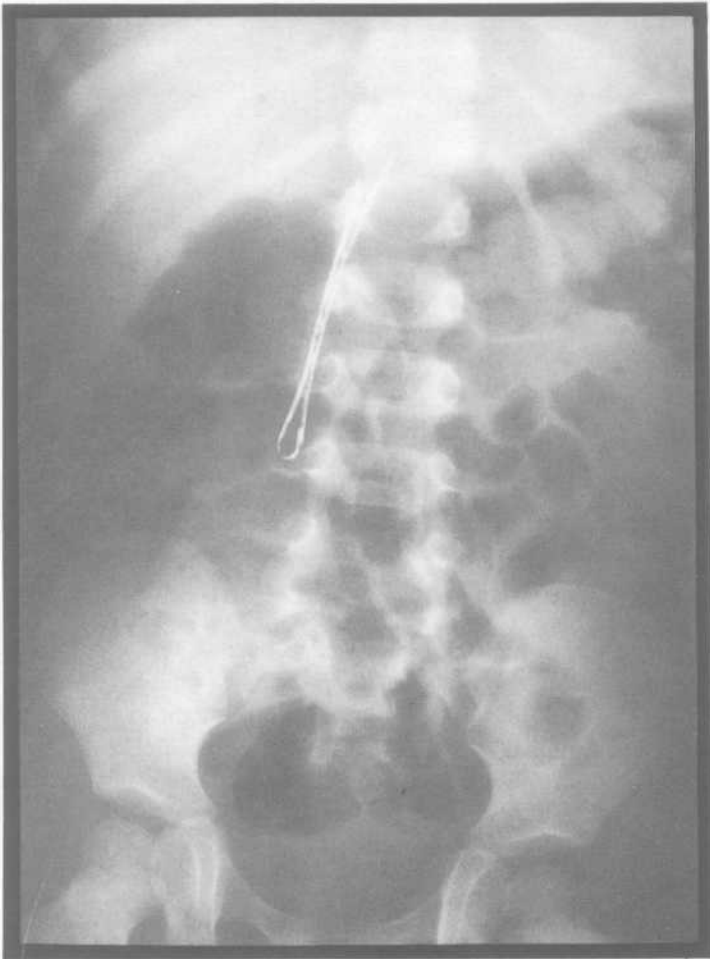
Plain x-ray of the abdomen showing the hair-pin in the wall of the second part of the duodenum.
